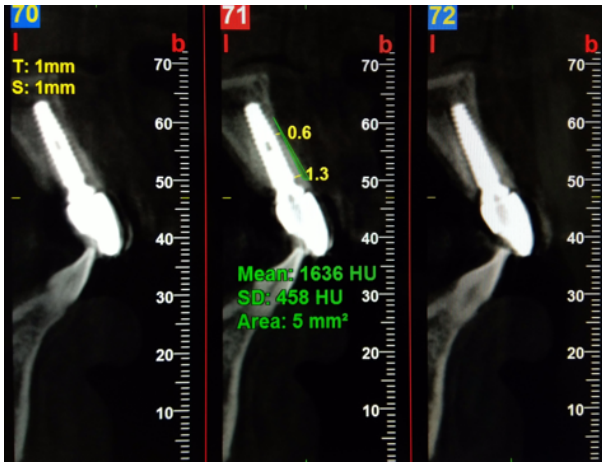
Radiographic assessment 7 months post-operative
